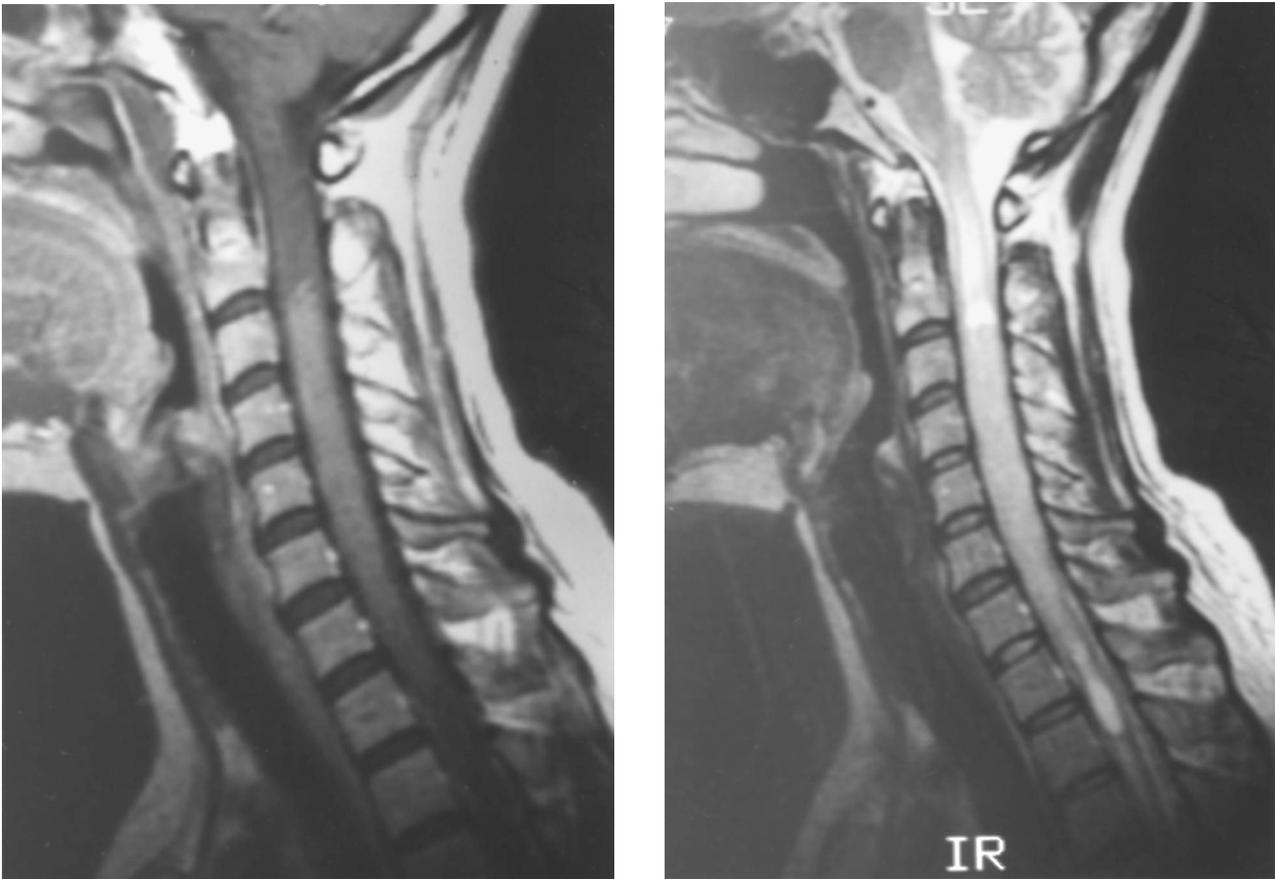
Case, 43-year-old, female. MR image (left: T1W Gd enhanced/right: T2W) demonstrated intramedullary spinal cord tumor at the level from C2 to Th1
